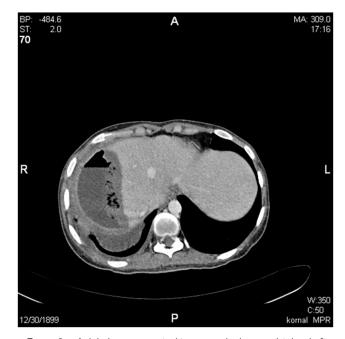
Axial plane computed tomography image obtained after surgery demonstrates fluid collection at the site of surgery, and air within the collection indicates infection.
